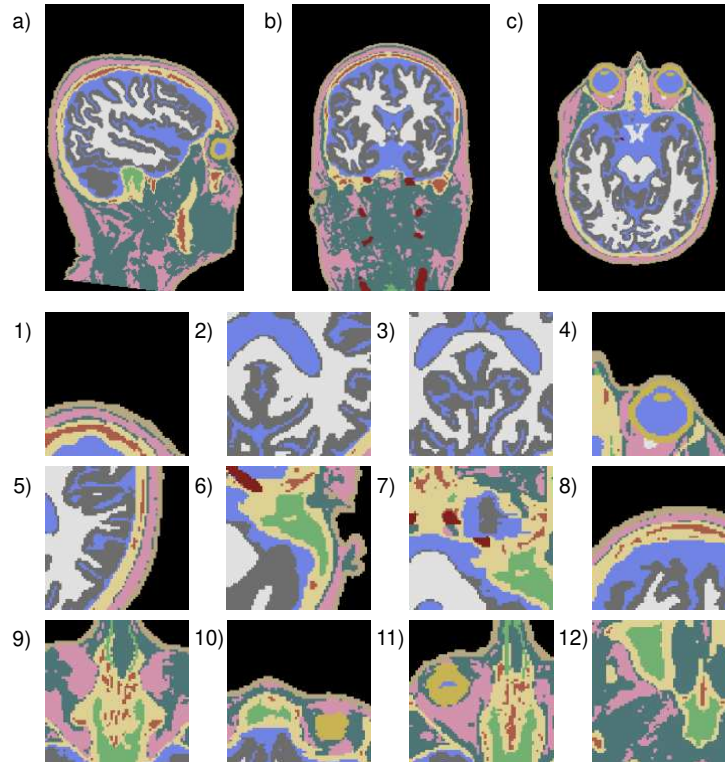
The training data loader generates 12 data samples of size $64 \times 64 \times 64$ per T1-MRI input. Each data label is the center pixel at least once. a) – c) represent the sagittal, coronal, and axial views of an original T1-MRI volume of size $256 \times 256 \times 176$. The patches have each of the following labels as its center pixel: 1) Background, 2) WM, 3) GM, 4) Eyes, 5) CSF, 6) Air, 7) Blood, 8) Cancellous Bone, 9) Cortical Bone, 10) Skin, 11) Fat, and 12) Muscle.
